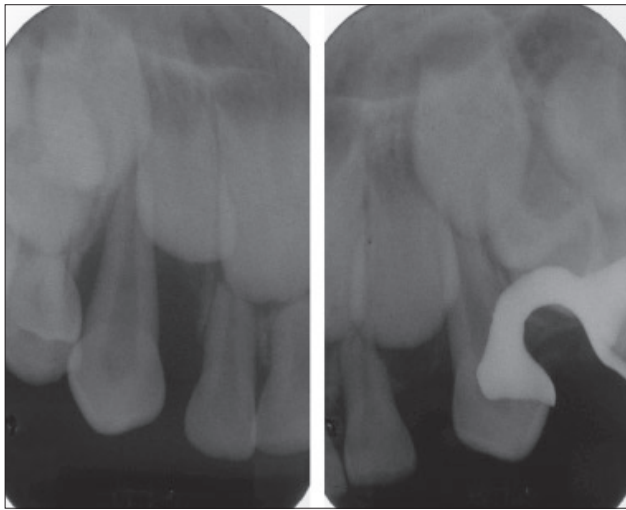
Periapical radiographs taken on January 9, 2002, of teeth C and H at age 6 years, 2 months.
